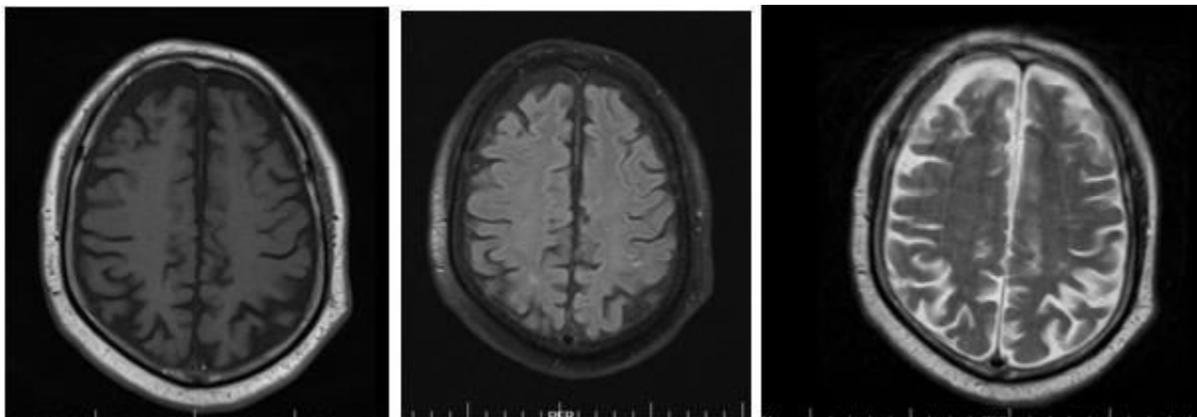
Left image; T1 WIs, Middle image; FLAIR image and right image; T2 WIs for the same patient in figure 1. There is no abnormal signal corresponding to the lesions seen on T2* WI in figure 1.
